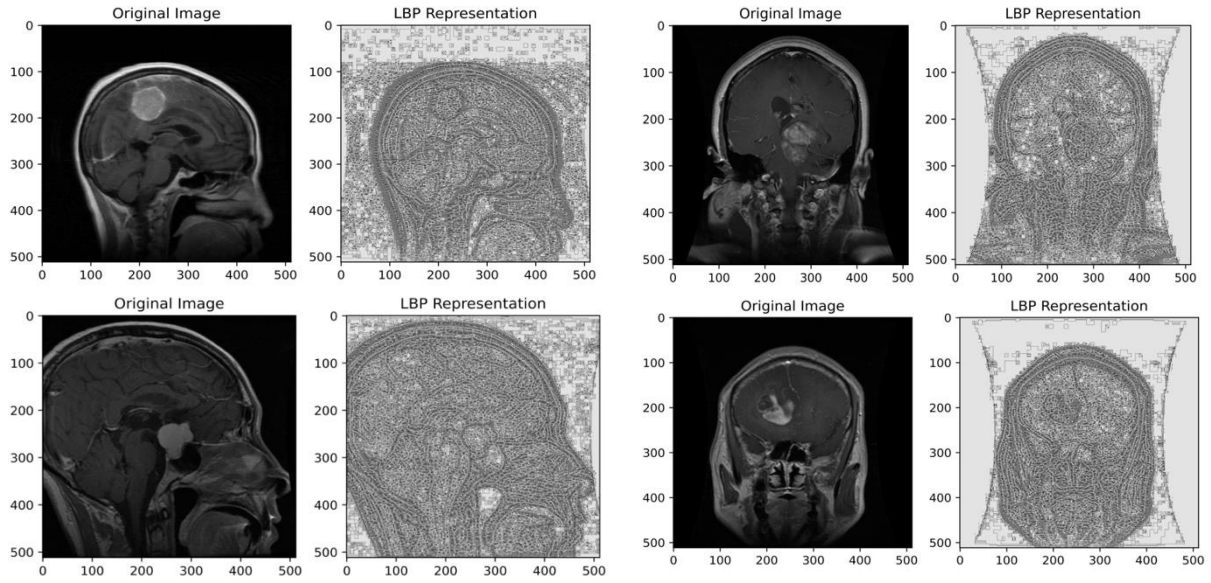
Local Binary Pattern (LBP) texture extraction on representative brain scans: Comparison between original multi-view MRI slices (left panels) and their corresponding LBP feature representations (right panels), demonstrating localized surface texture variation in tumor regions
